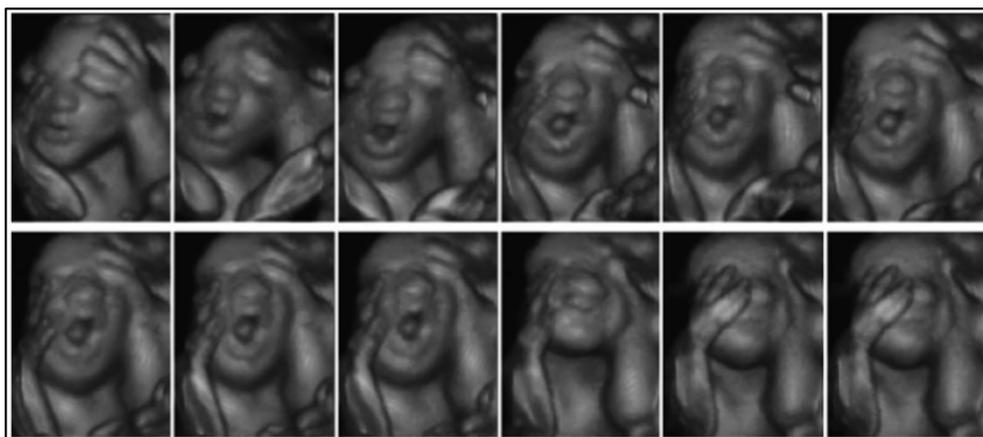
3D US serial imaging showing an ample, slow, and very deep inspiration, with the mouth wide open in foetal yawning during the second to third trimester. Note the generalized stretching of muscles in the face and neck (With permission from Wolfgang Moroder (Photographer) in *The Ultrasound Review of Obstetrics & Gynecology*, 2005) (Travail personnel) [CC-BY-SA-3.0 <http://creativecommons.org/licenses/by-sa/3.0>)]
